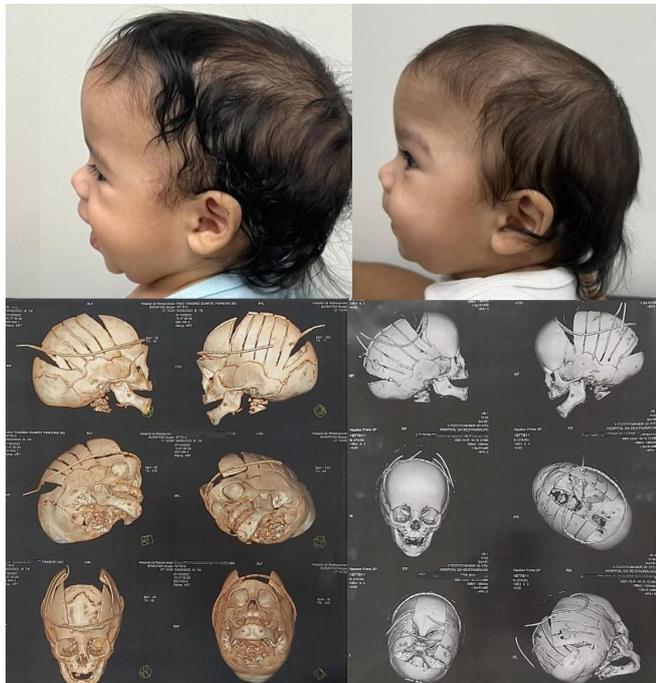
pre operative pictures of the patients and post operative CT scan
